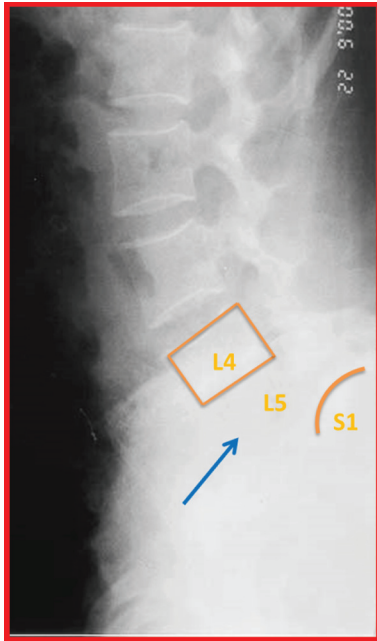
Radiograph after first-stage procedure. Vertebral body of L5 was removed.
